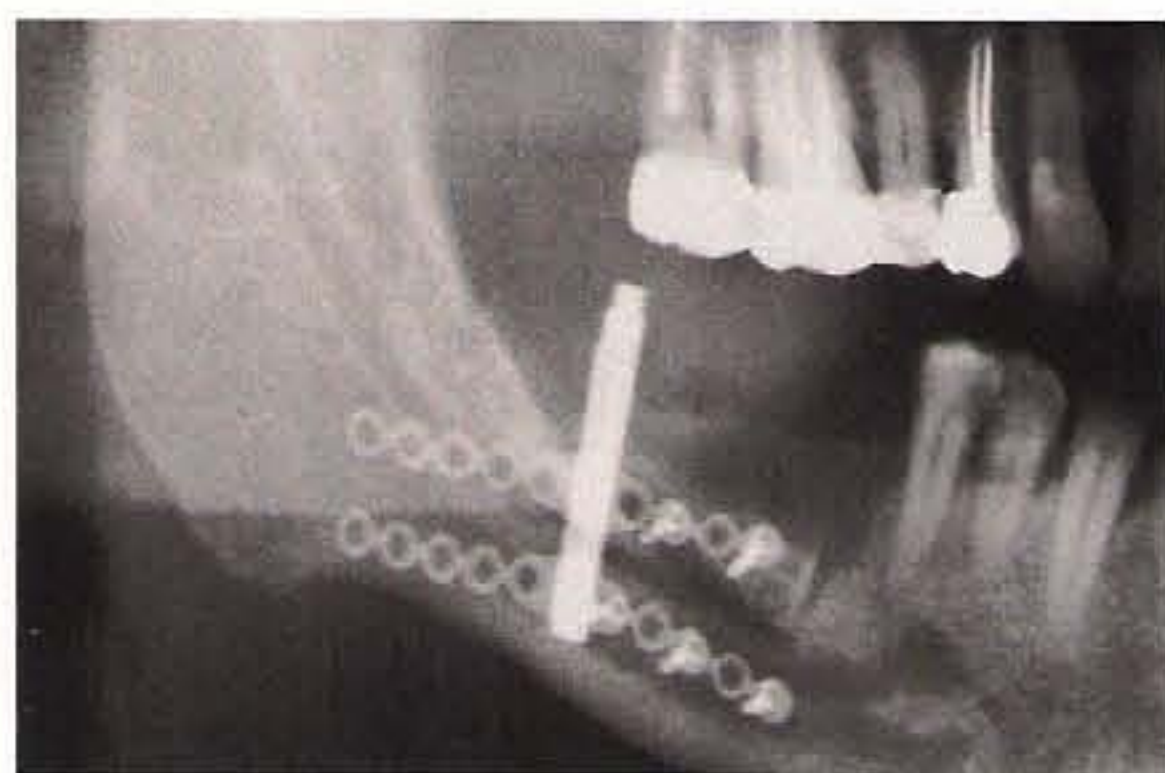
A panoramic radiograph is taken after the procedure, to confirm the correct positioning of the distractor.
